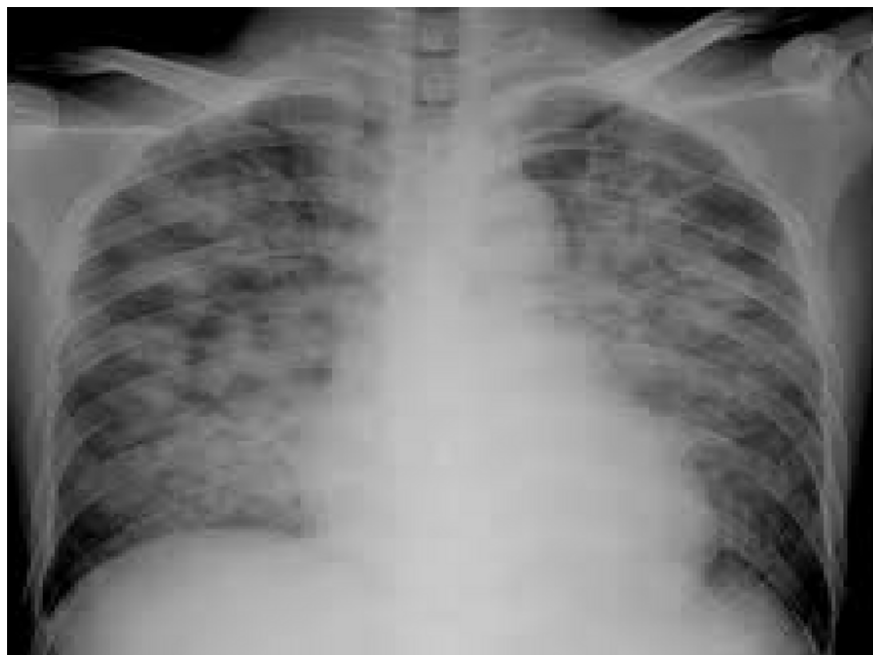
Chest X-ray in AP view demonstrated diffuse bilateral infiltration, both in upper and lower lobes, without any evidence of pleural effusion.
